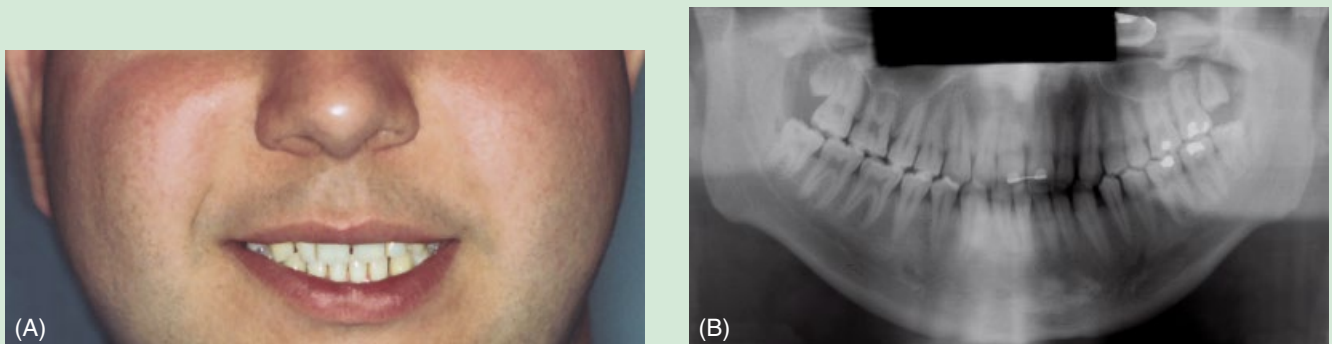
The patient 10 years after the end of the treatment (A). Orthopantomograph; notice that tooth #9 is still vital (B).
